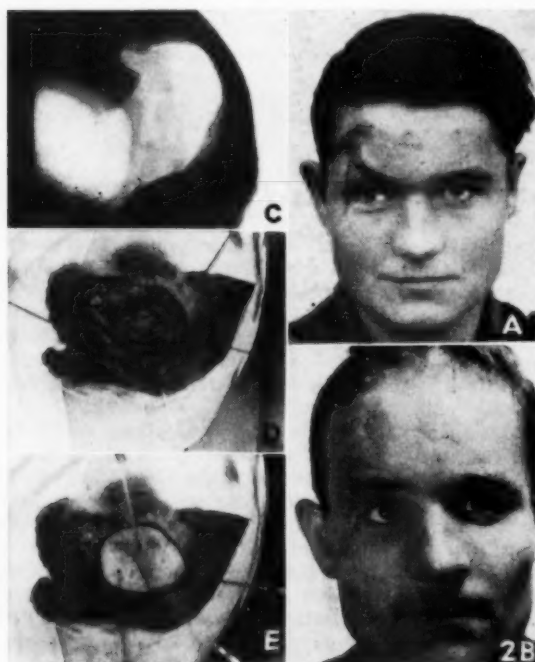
Case 1. (a) Pre-operative picture showing pulsating defect in skull in frontal area. (b) Post-operative. (c) X-ray showing defect. (d) and (e) Manner of replacing and fixing bone.
